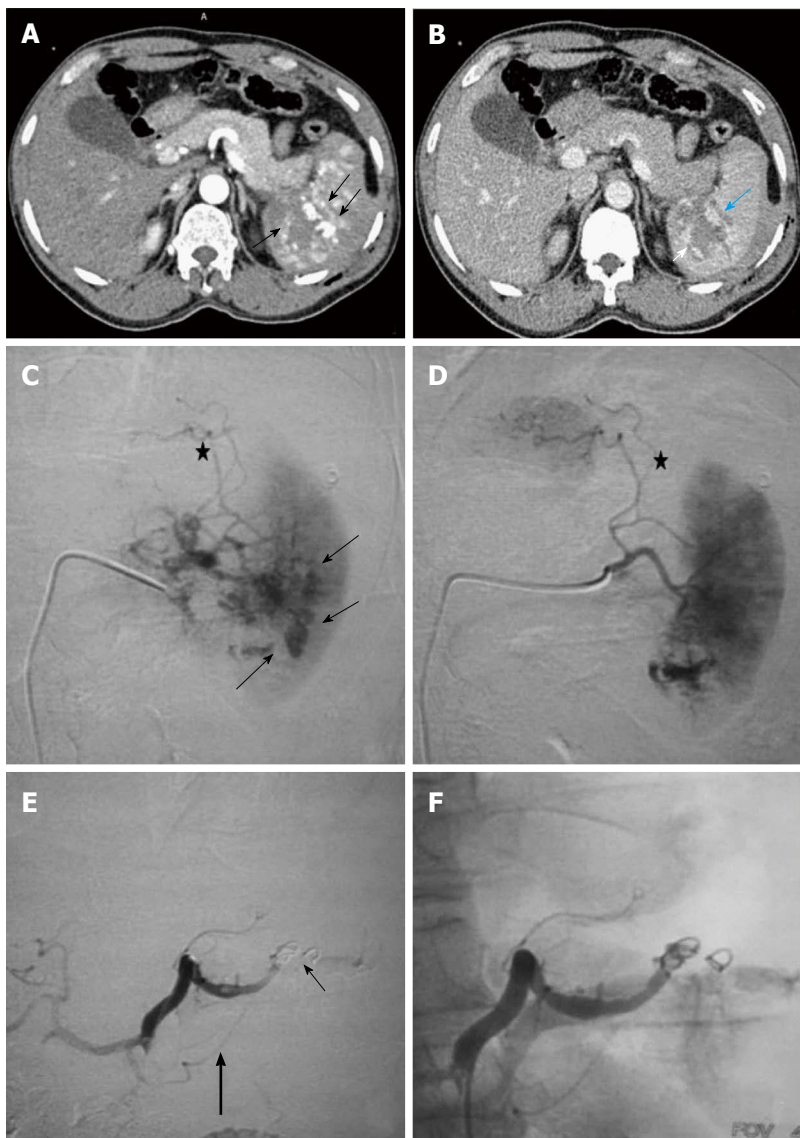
Grade IV splenic injury with active contrast extravasation in a 29-year-old male with blunt trauma abdomen, hemodynamically stable and FAST positive. Arterial phase image (A) showing blobs of contrast (arrow) marginating the deep splenic laceration. In portovenous phase (B), lacerations are better appreciated, few of which are involving splenic hilum. Also, blobs of contrast in the arterial images has slight increased in size (arrow), nonetheless, remain localised s/o focal active contrast extravasation. DSA was done (C and D), selective splenic artery angiogram showed multiple areas of active contrast extravasation from trabecular arteries of lower pole (arrow) with disruption of parenchymal continuity due to laceration (asterisk). Proximal embolization of splenic artery was done with coil followed by gelfoam instillation (E). Note coils (thin arrow) are deployed distal to the origin of dorsal pancreatic artery (thick arrow). Post embolization angiographic run (F) showed proximal contrast stasis with no opacification distal to embolization site. DSA: Digital subtraction angiography; FAST: Focused assessment with sonography in trauma.
